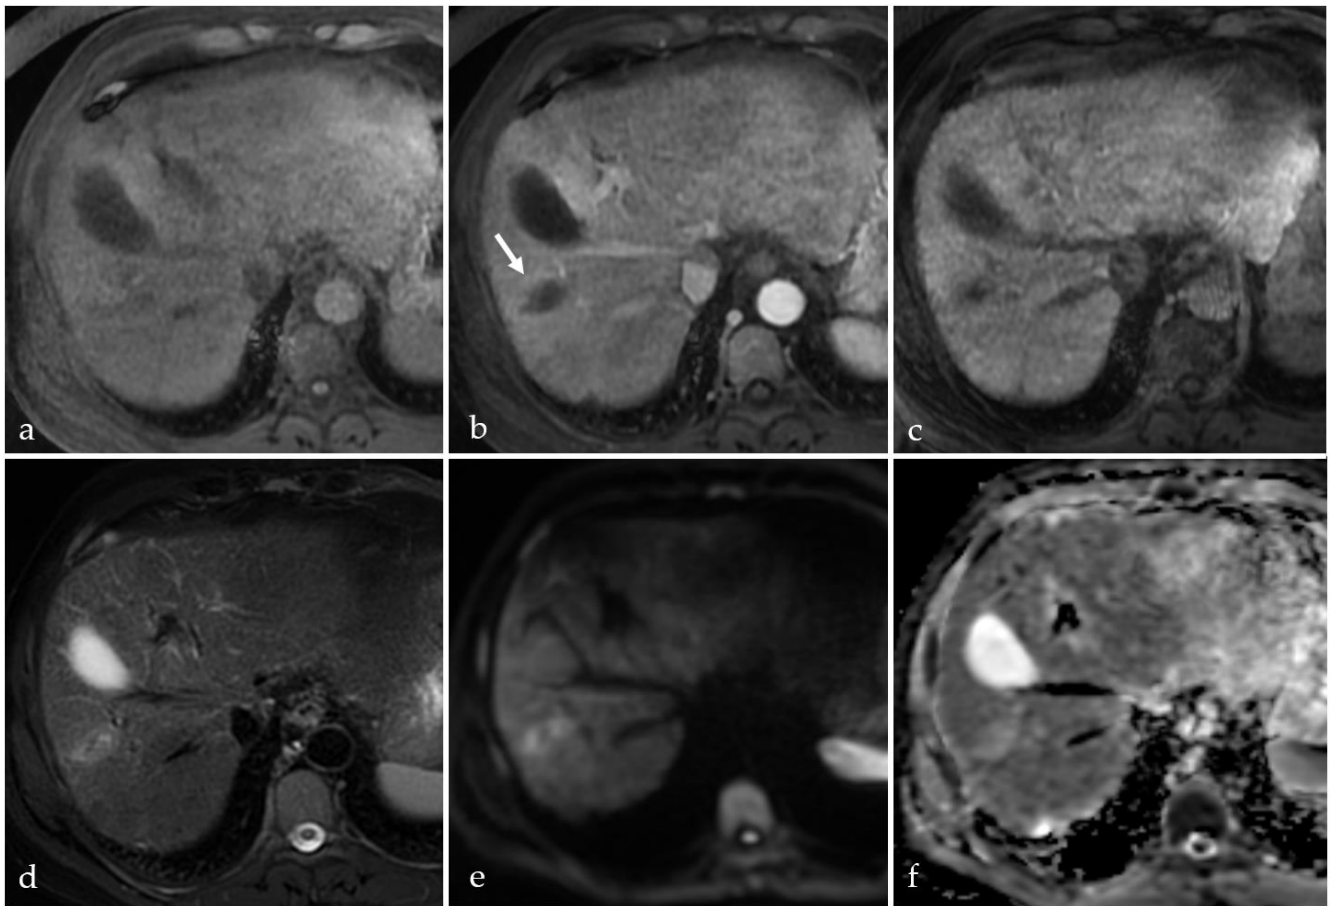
MRI examination of an HCC nodule in the right liver lobe, treated with MWA 2 months prior. (a) T1 weighted image with fat suppression; (b)—subtraction image; (c)—T1 WI with fat suppression in the hepatobiliary phase (at 20 min); (d)—T2 weighted image with fat saturation; (e)—diffusion weighted image; (f)—apparent diffusion coefficient map. Arrow in figure a points to an ellipsoid area of ablation, with MRI features of coagulative necrosis, but low signal intensity is observed on the T2\* sequence (g), suggestive of chronic hemorrhage.
